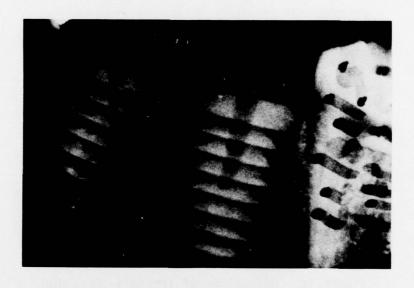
RADIOGRAPH OF ALUMINA IMPLANTS SHORTLY AFTER PLACEMENT. FIRST MOLAR AND SECOND PRE-MOLAR MANDIBULAR
